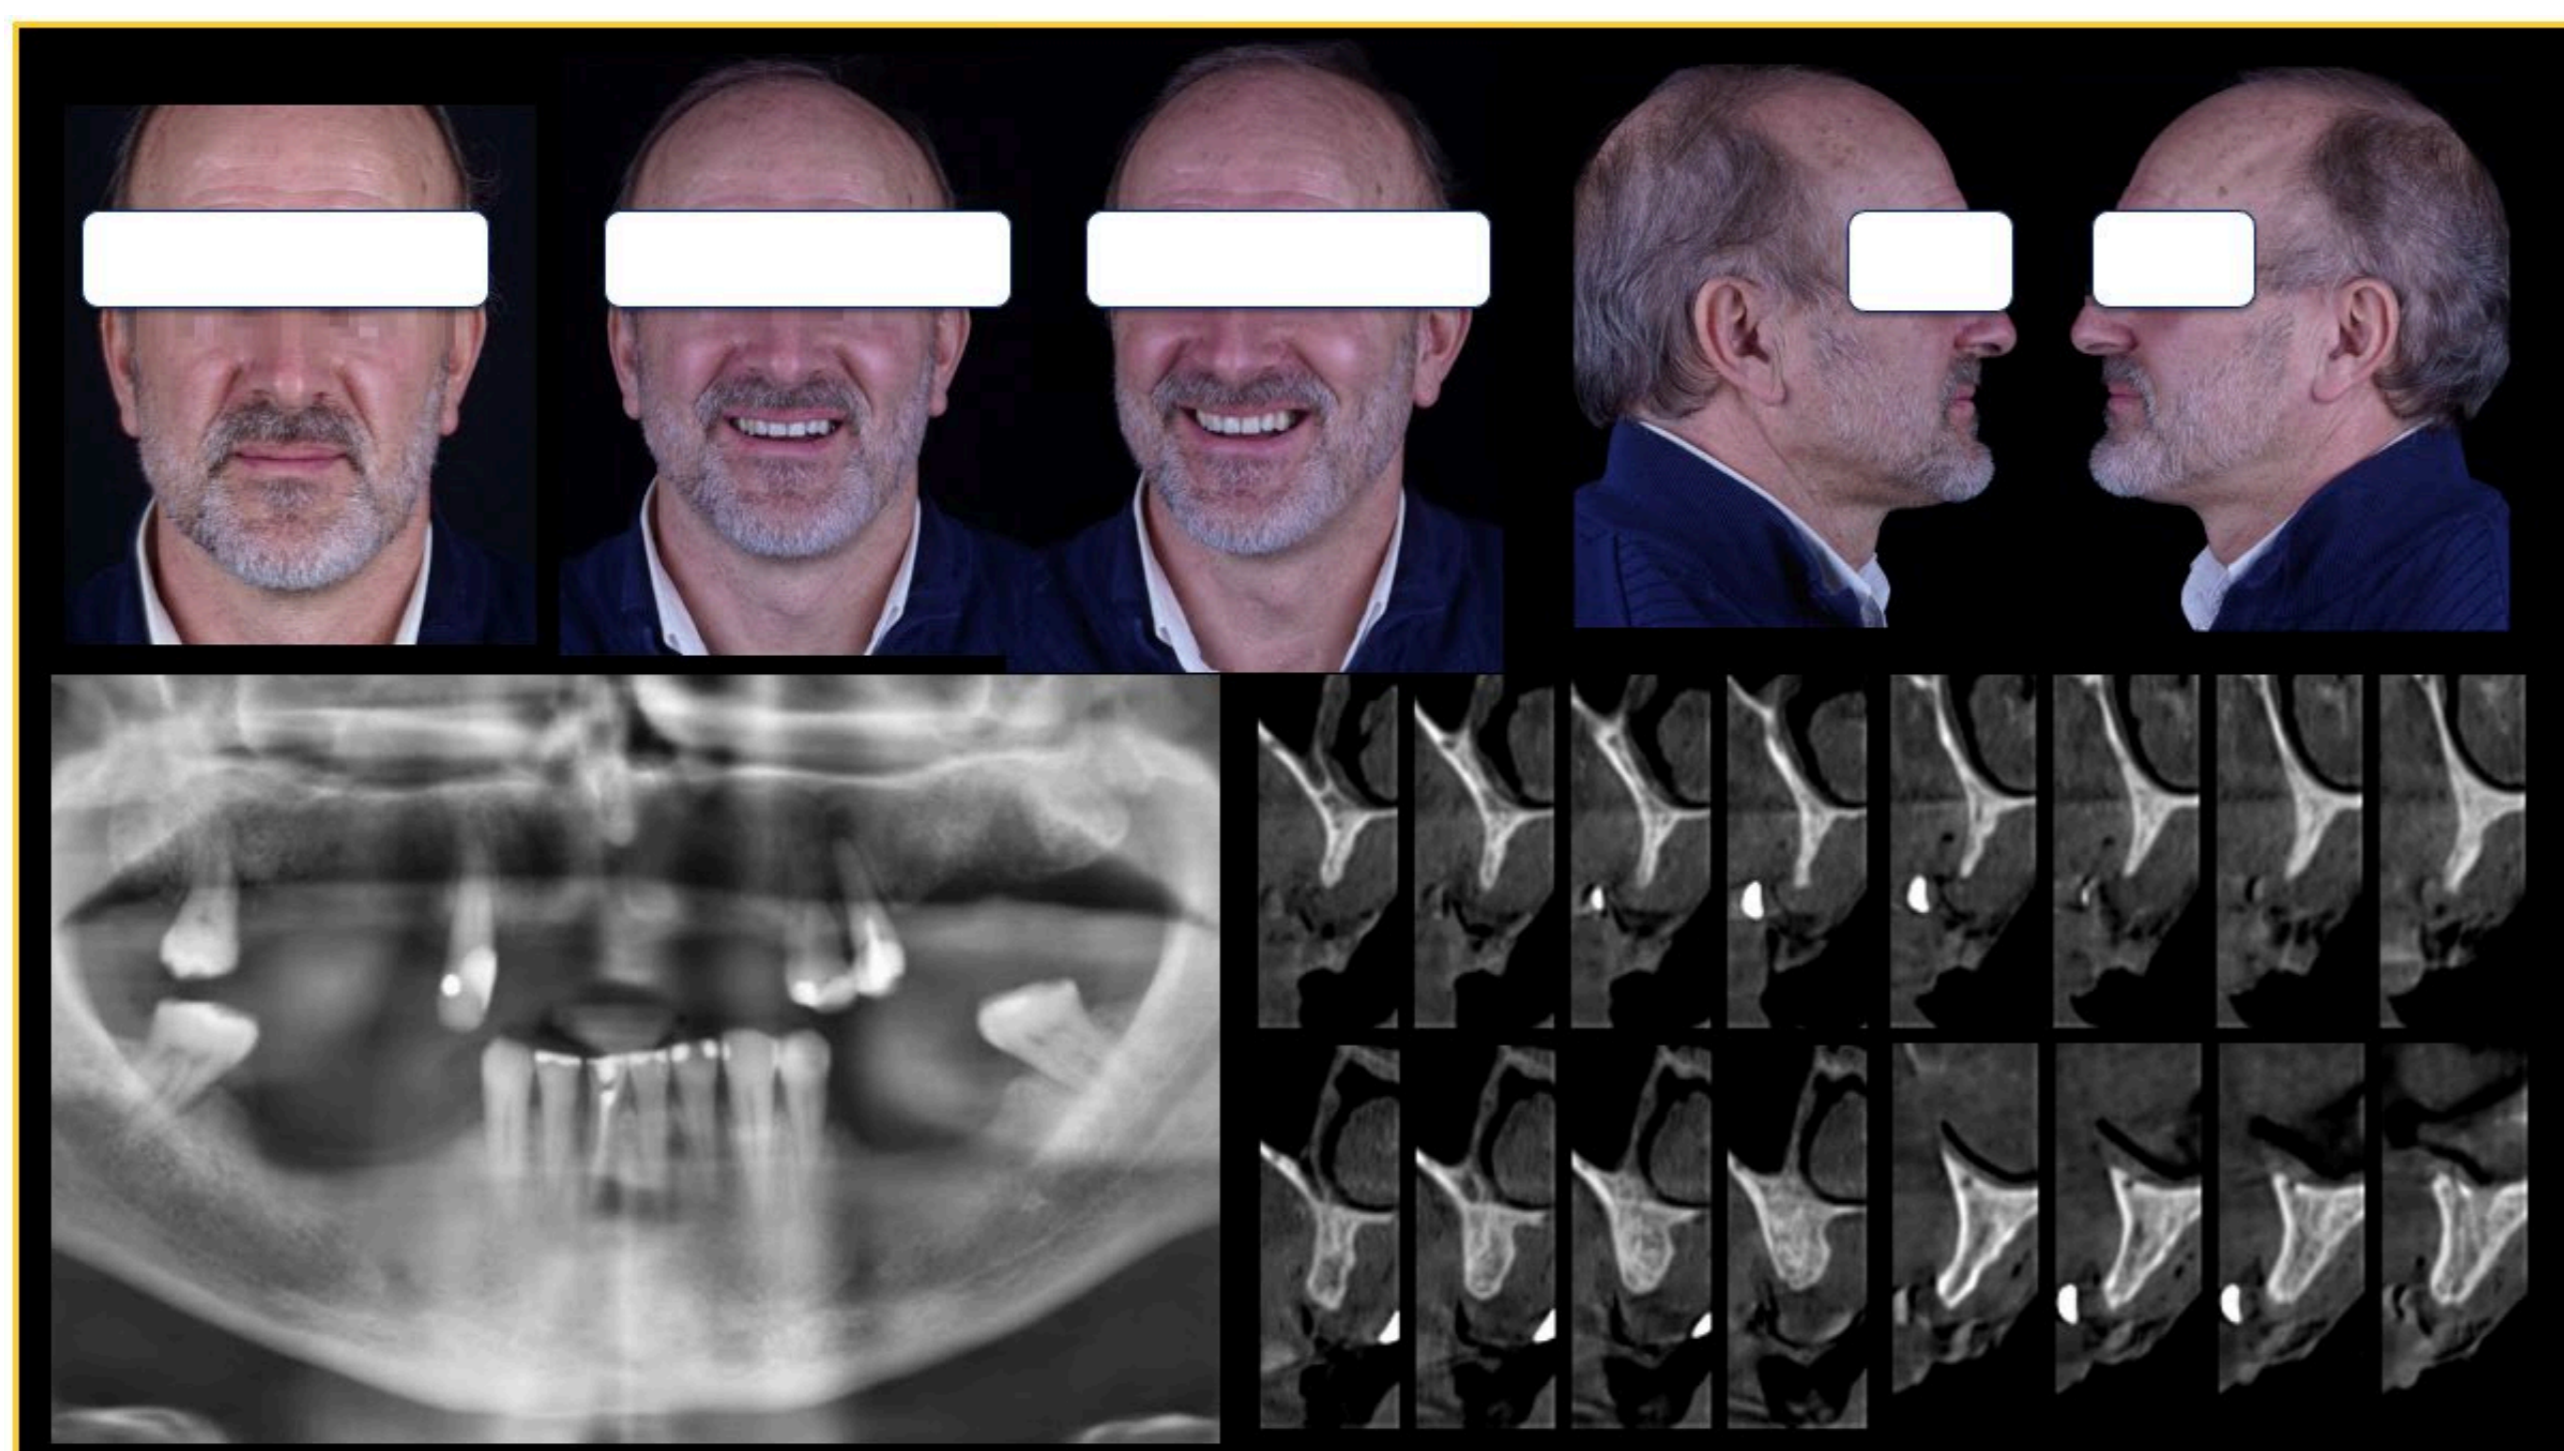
Patient initial status, Ortopantomography and CBCT
